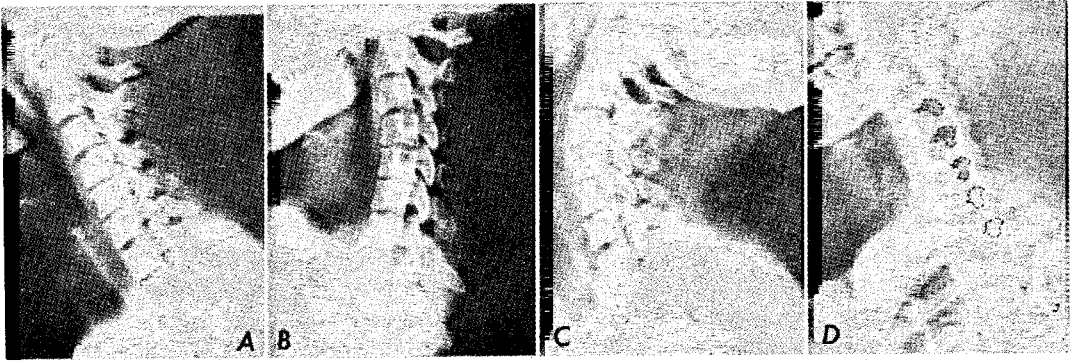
The Davis series of lateral roentgen films and an oblique view showing the intervertebral foramina. The straight lateral view (A) shows a loss of the forward curve and a narrowing of the intervertebral disks between C4 and 5 and C5 and 6. Flexion view (B) shows anterior subluxation of C3 on 4. Hyperextension view shows posterior subluxation of C3 on 4. The fourth, the fifth and the sixth vertebrae are fairly well fixed, so that very little motion occurs in this area. Oblique view (D) shows narrowing of the intervertebral foramina between C4 and 5 and C5 and 6.
